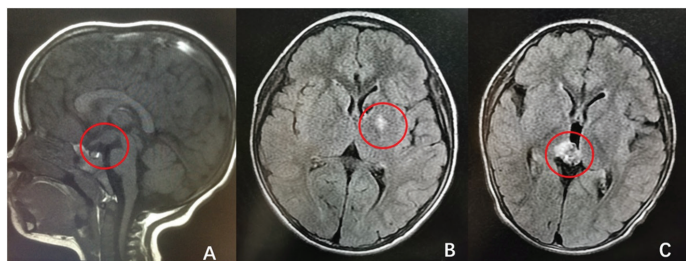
Pathological brain magnetic resonance imaging from three representative cases: Hypothalamic hamartoma (A), basal ganglia germ cell tumor (B), and choriocarcinoma (C)
